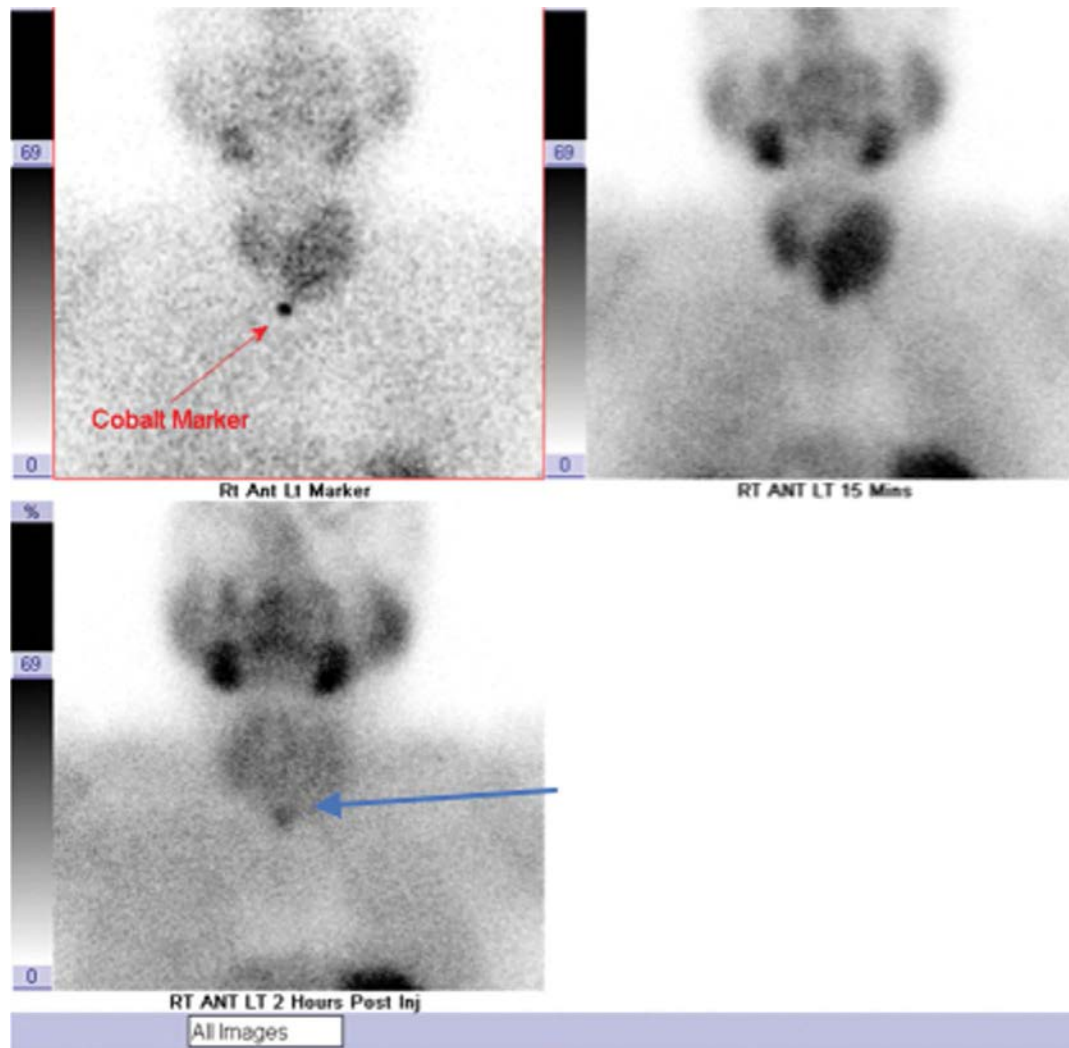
(A) Early and late planar images demonstrating a solitary region of [<sup>99m</sup>Tc]MIBI uptake on delayed imaging indicating the presence of a parathyroid adenoma; (B) Single slice from early (15 mins) and late [(C), 2 hours] SPECT/CT axial reconstruction on the same patient demonstrating sustained uptake of [<sup>99m</sup>Tc]MIBI in the region of suspected adenoma
